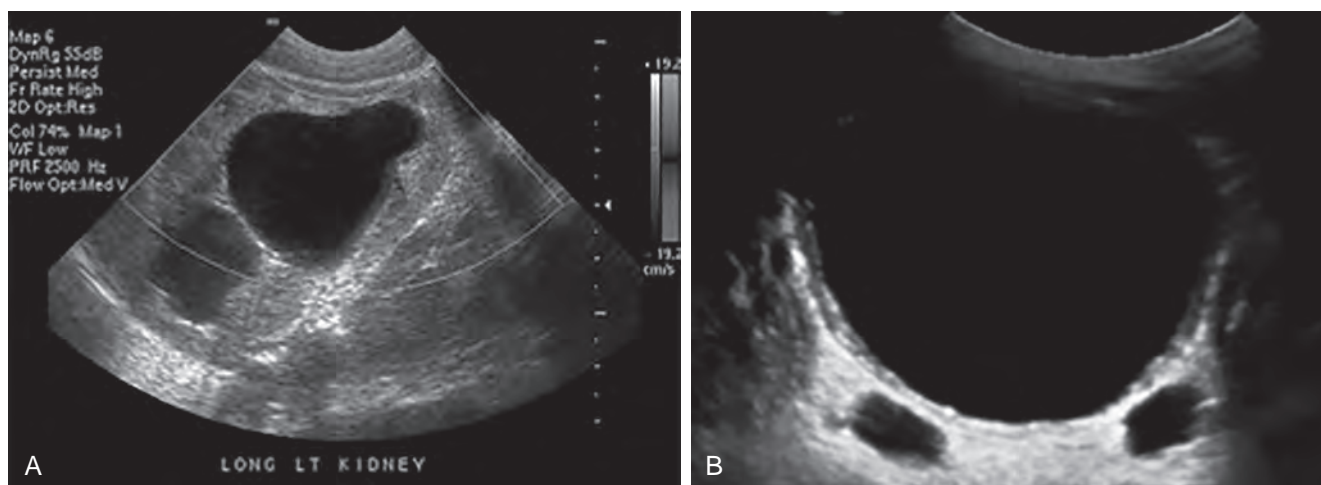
A, Left renal sonogram in a newborn with posterior urethral valves shows severe pelvocaliectasis with thinning of the parenchyma with increased echogenicity and loss of corticomedullary differentiation. B, Pelvic view of same patient, not yet catheterized, shows a distended bladder with dilation of bilateral distal ureters.
